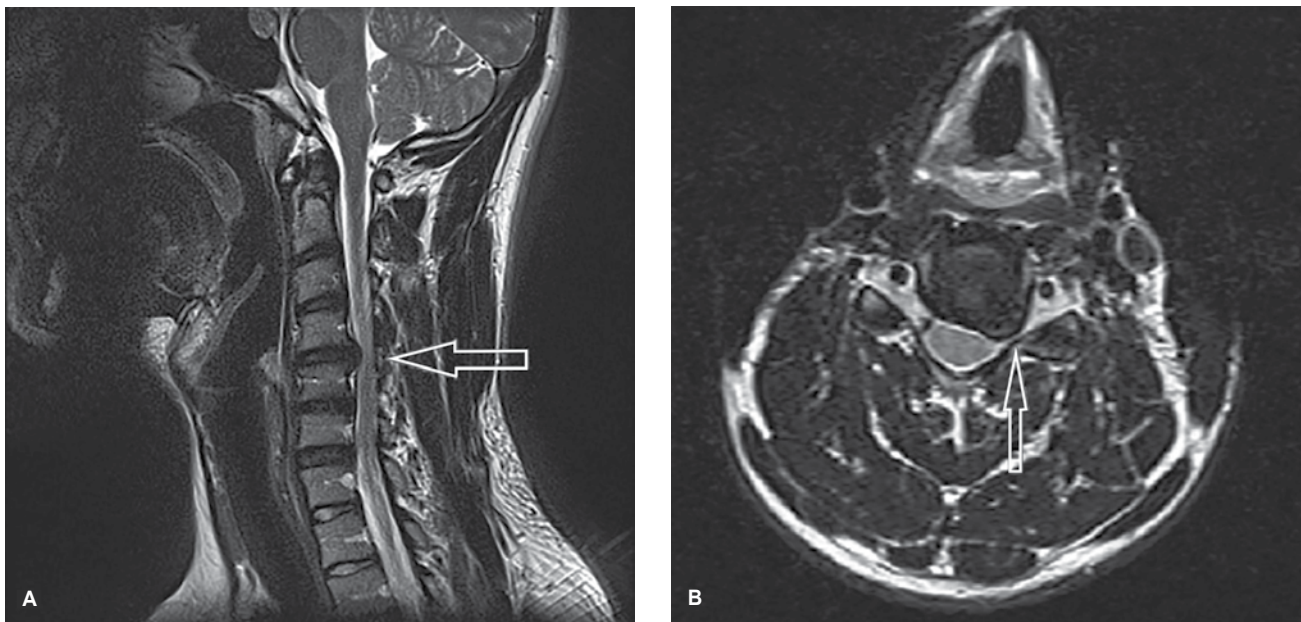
T2-weighted cervical magnetic resonance imaging. (A) Sagittal view of a large paracentral/foraminal disk protrusion at the C4-C5 level indenting the anterior thecal sac and flattening the anterior surface of the cord. (B) Axial view of the same lesion. The disk protrusion caused severe left intervertebral foraminal stenosis and compressed the left C5 nerve within the foramen.
